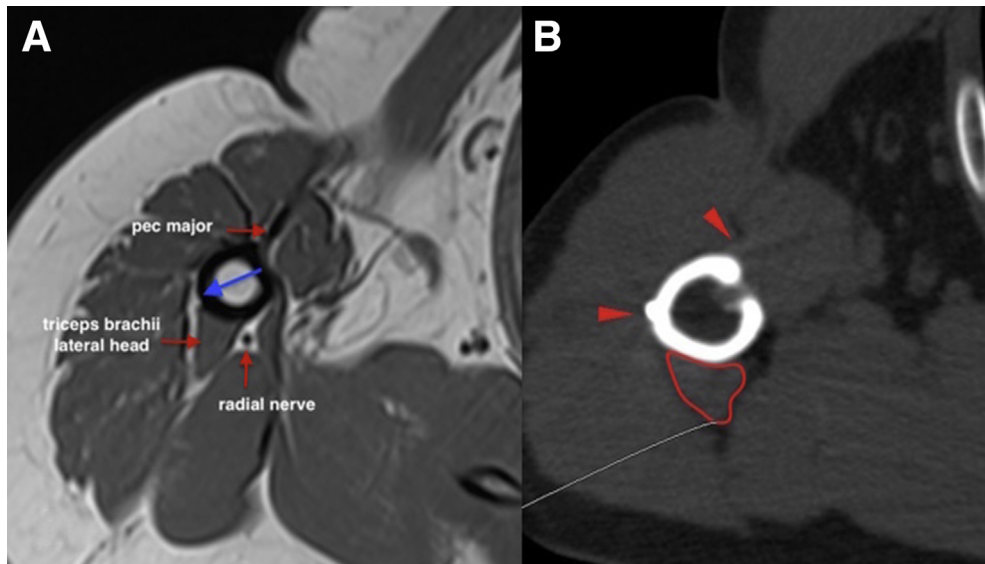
Axial cuts of a right shoulder. (A) Preoperative magnetic resonance image: a drilling axis (blue long arrow) performed orthogonally on the LHBT groove at 1 cm proximal to the inferior border of the pectoralis major tendon insertion will perforate the far cortex at least 2 cm away from the radial nerve. (B) Postoperative CT scan shows LHBT inside the bone tunnel and metallic button (arrow on left) lateral to the triceps brachii lateral head (outlined). The pectoralis major insertion (arrow on top) is visible just lateral to the humeral hole. (LHBT, long head of the biceps tendon.)
